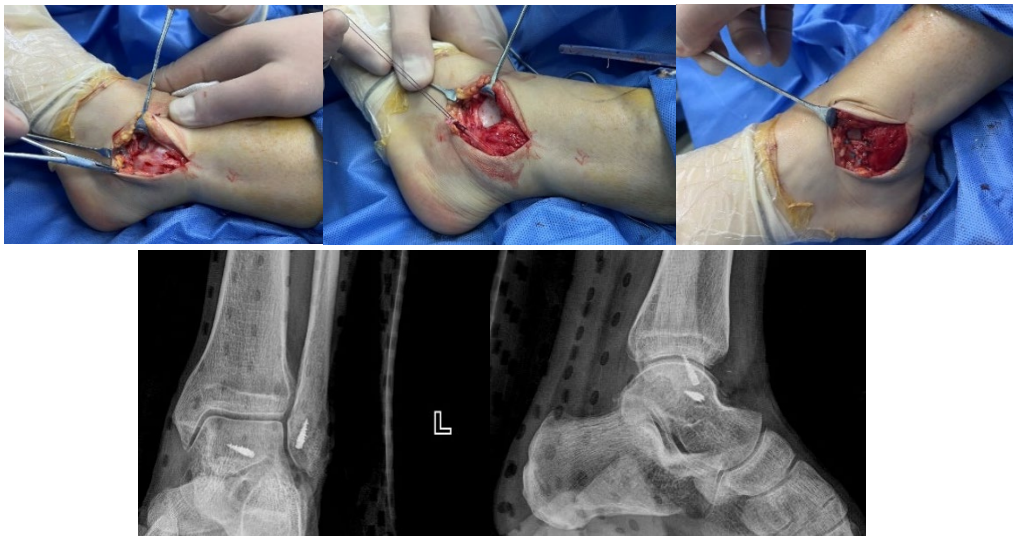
Anterior talofibular ligament reconstruction and X-rays after the procedure
